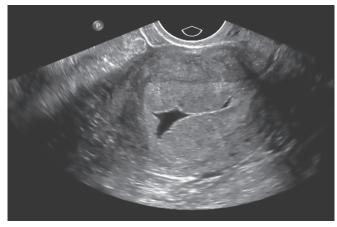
Saline infusion sonography reveals diffusely thickened endometrium
